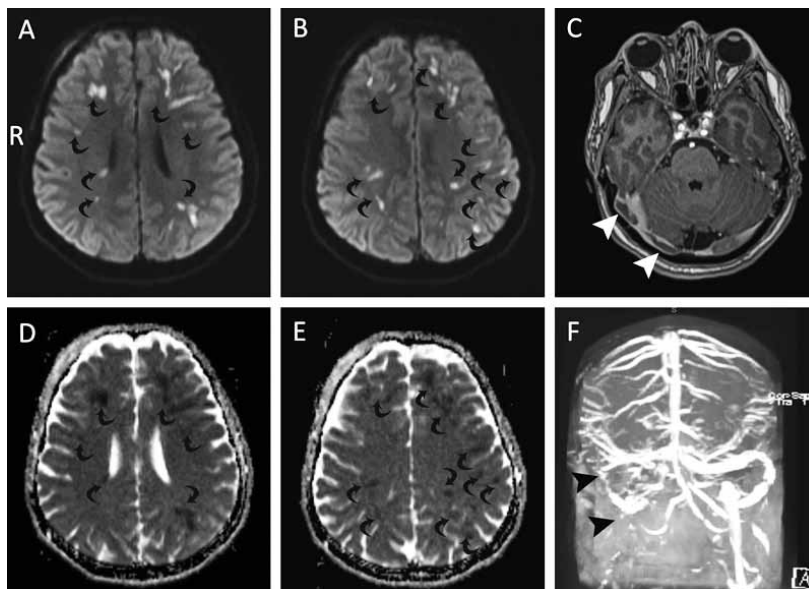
Axial cranial MRI showing: A & B) Diffusion weighted image (diffusion sensitivity factor $b=1000 \text{ sec/mm}^2$); C) Post contrast T1 weighted image. D & E) Corresponding apparent diffusion coefficient map. F) Time-of-flight MR venogram.
